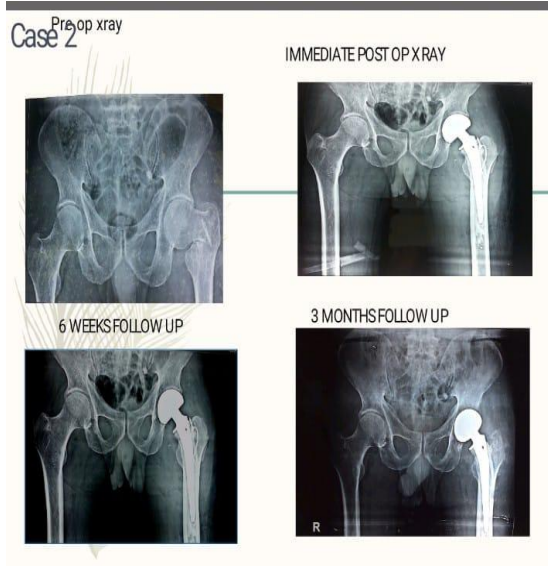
Case 2 pre-operative X ray and post-operative x-ray, 3- & 6-month follow-up x ray
